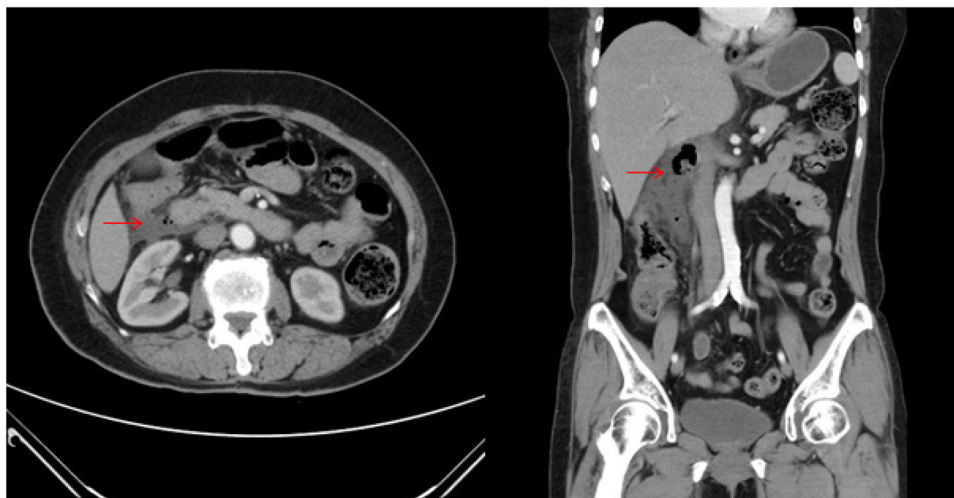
CT scan evidencing a perforation of duodenum diverticulum with retroperitoneal free air and fluid retention.
